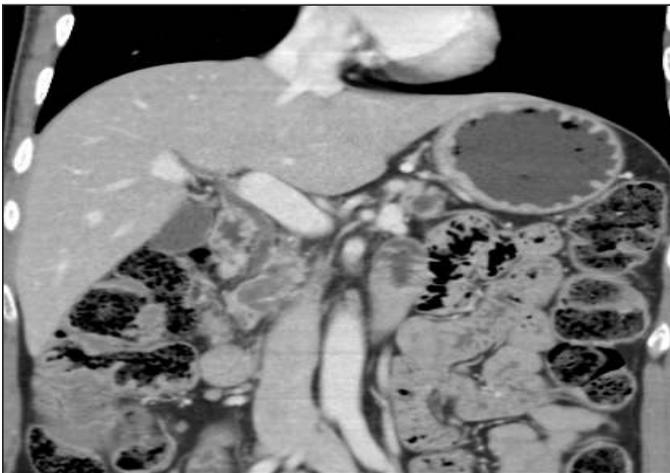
Same patient in coronal enhanced CT slice showing normal caliber of CBD with dilated tortuous duct containing subtle high density material suggestive of IPMT.
